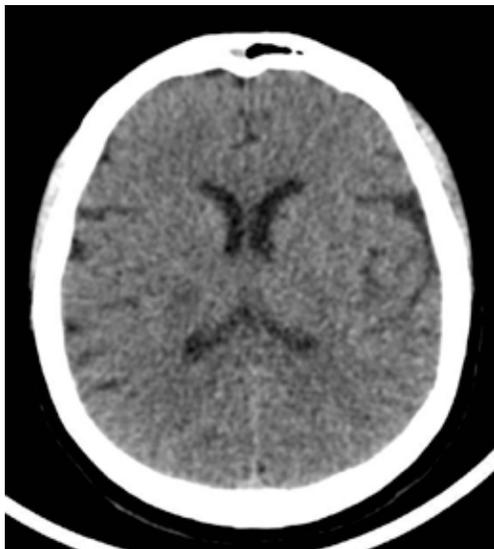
Normal brain CT 2 years later.
